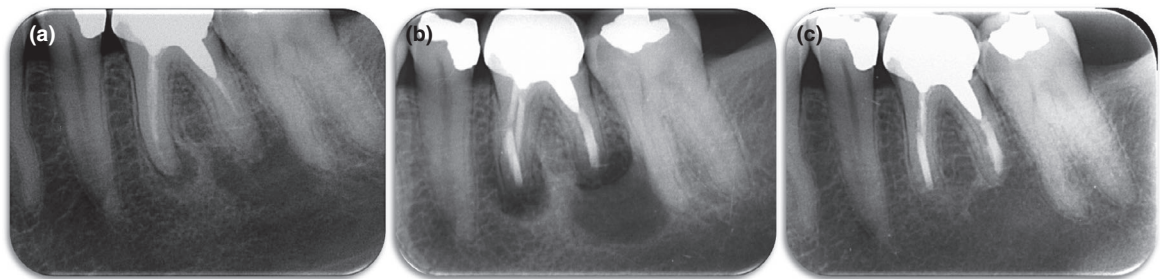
Tooth No. 36—Retrograde root canal retreatment. (a) Preoperative radiograph. (b) Postoperative radiograph demonstrating minimal resection and a retrograde preparation as coronal as practical. (c) 1-year follow-up showing complete healing.
